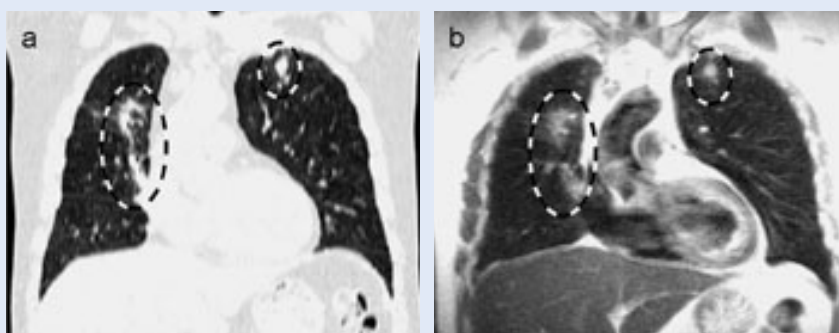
Discrete atypical infiltrates in immunosuppressed patient. Multi-detector HR-CT (a) and iPAT HASTE MRI (b).
